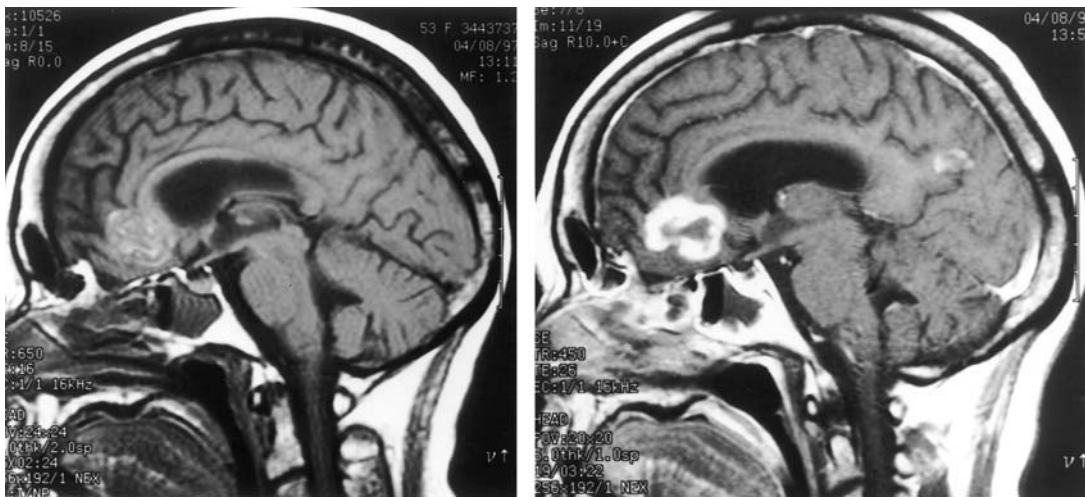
Sagittal T1-weighted images without (left) and with (right) gadolinium enhancement in a patient with AIDS, demonstrating the typical heterogeneous rim enhancement seen with primary CNS lymphoma in this population of patients.
